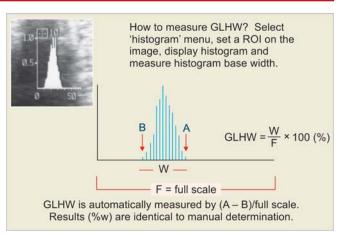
GLHW is measured by common ultrasound B-mode. Select histogram menu, set the ROI on B-mode image, display histogram, measure the base width (W) and full gray scale (F). GLHW = W/F (%). Automatically measured GLHW (%W) determined by A-B was identical to manual determination
